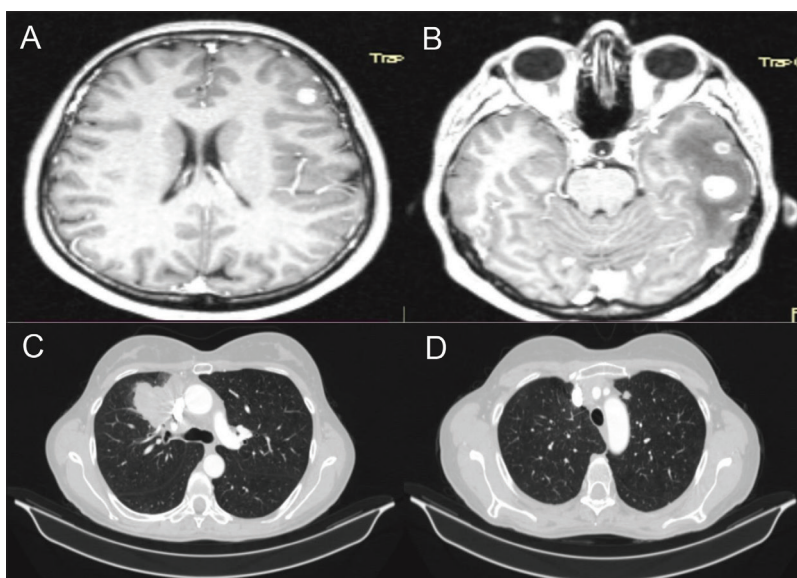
Magnetic resonance imaging of the brain revealing brain metastases in the left frontal and temporal lobes (A, B); multi-slice computer tomography of the chest showing tumor mass in the right upper lobe (C), and a spiculated nodule in the left upper lobe (D) as well as mediastinal lymphadenopathy
